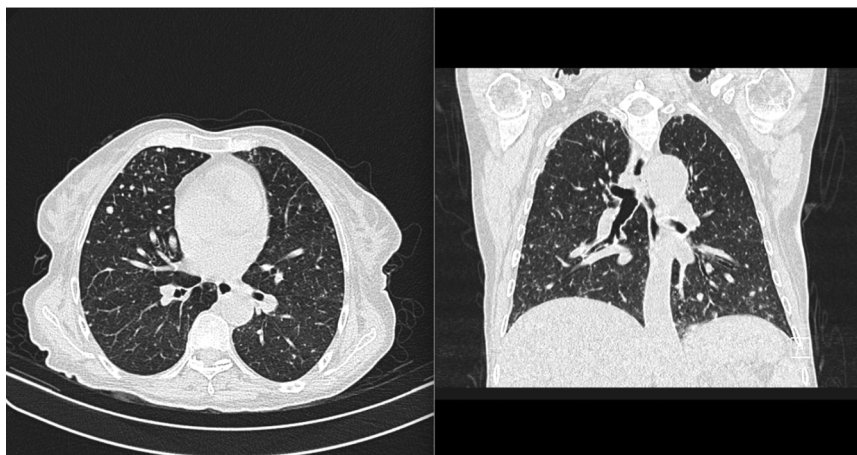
Liver recipient chest computed tomography showing multiple nodules with miliary pattern compatible with secondary implants.
